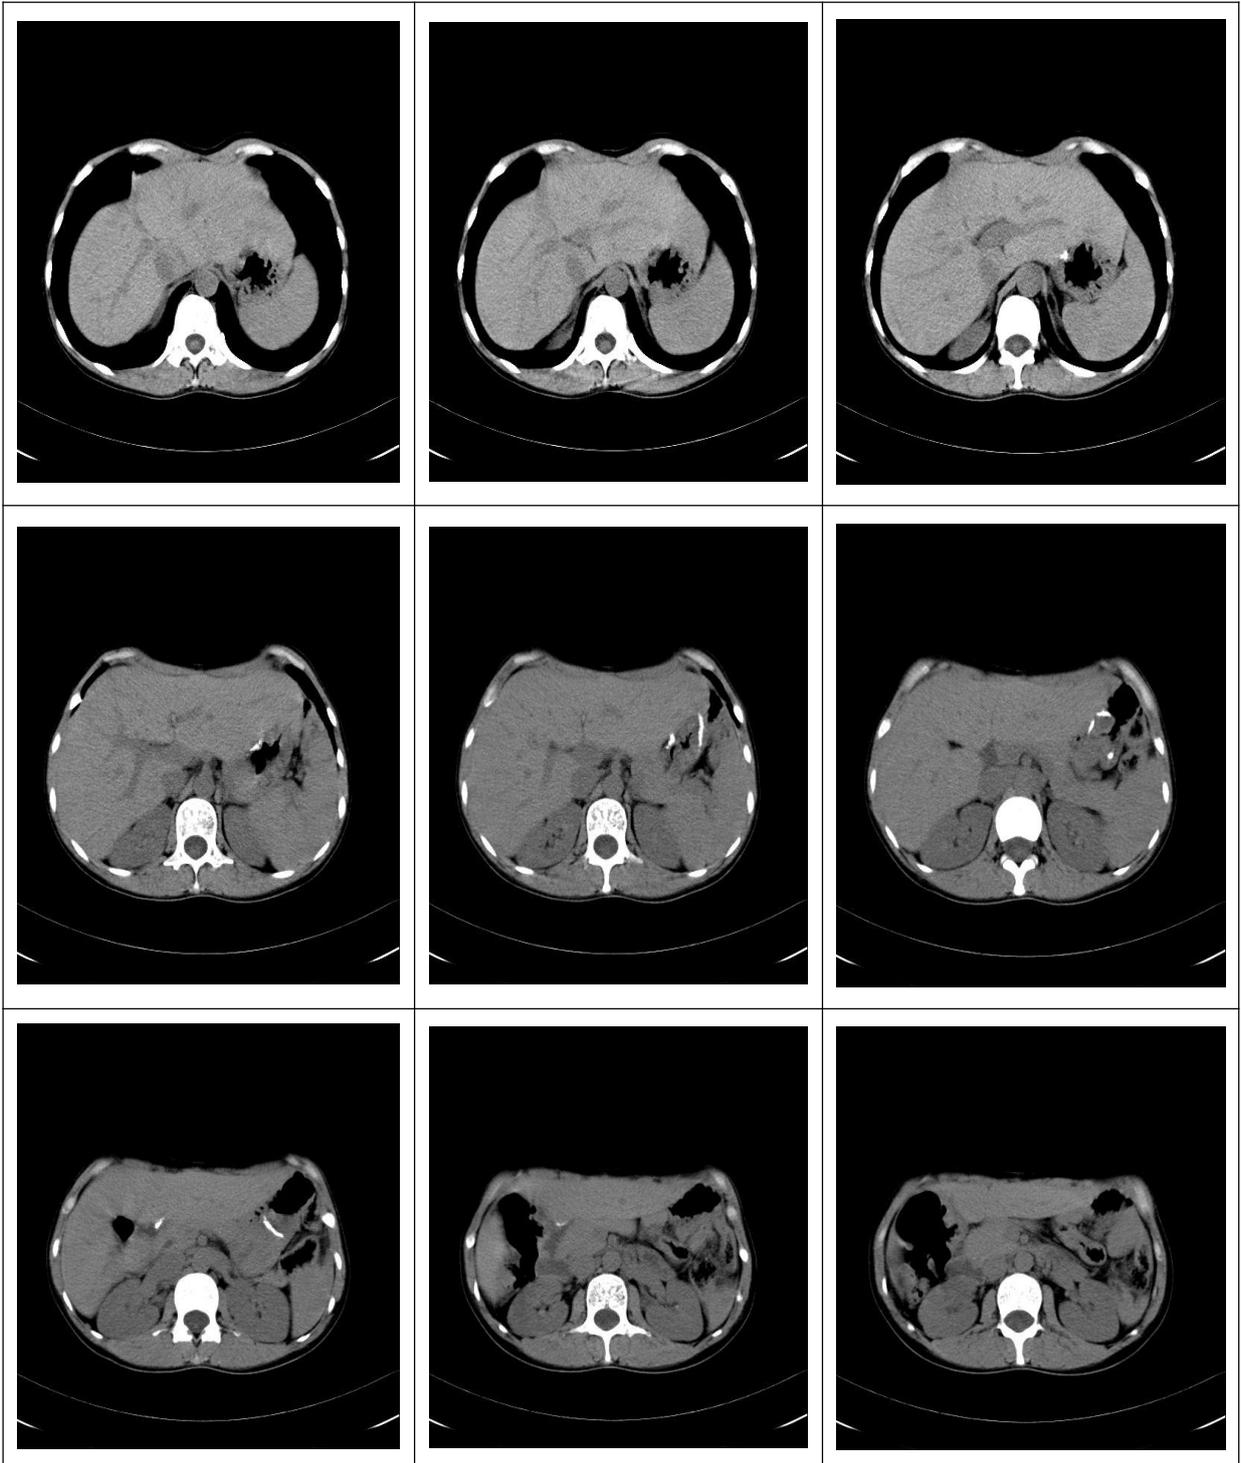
Selected Postoperative Abdominal CT Image
